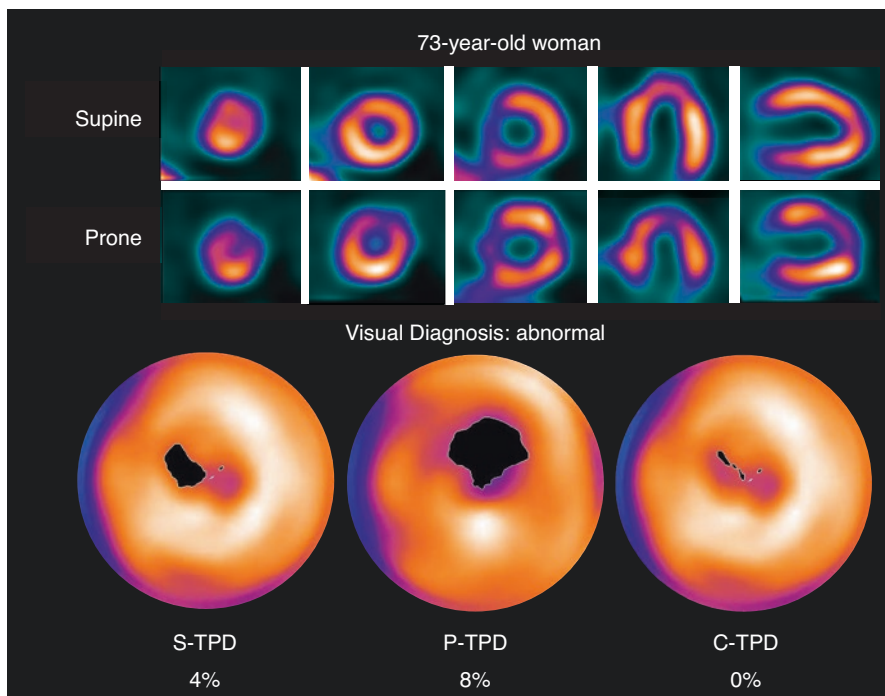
Case example of two-position imaging. In this case, combining supine and prone imaging offers superior visual interpretation but was still interpreted as abnormal. Quantitative perfusion analysis is also improved by integrating supine total perfusion deficit (S-TPD), and prone TPD (P-TPD) into a single, combined measure (C-TPD) which shows no perfusion deficit. The patient had no significant coronary disease on invasive coronary angiography. (Case from REFINE SPECT registry)
